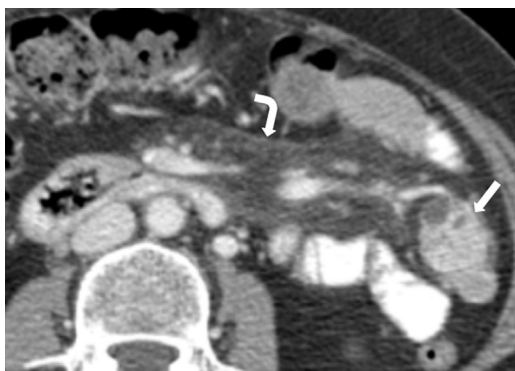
Heterotopic pancreas. A 69-year-old woman with abdominal pain and bloating; clinical concern was for ovarian cancer. Axial CT image from a CT performed with oral and intravenous contrast demonstrates a circumscribed mass along the serosal surface of a jejunal loop (*arrow*), predominantly solid, but also containing a few cysts. Findings were thought to be most likely due to a GIST; however, intraoperative and pathologic findings revealed heterotopic pancreas, which was causing acute pancreatitis. Note fat stranding of the small bowel mesentery from acute inflammation (*curved arrow*).
